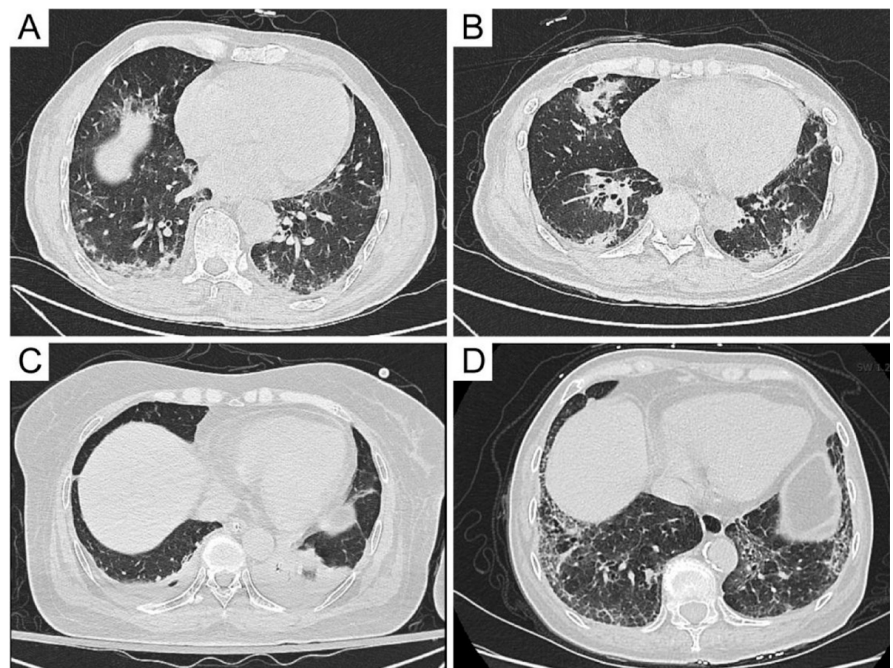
Various types of HRCT patterns and images.
